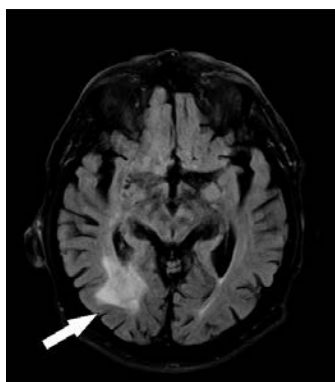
MRI, tumour infiltration in right occipital lobe (arrow) that later was confirmed as DLBCL (same patient as in Figure 5.7)
